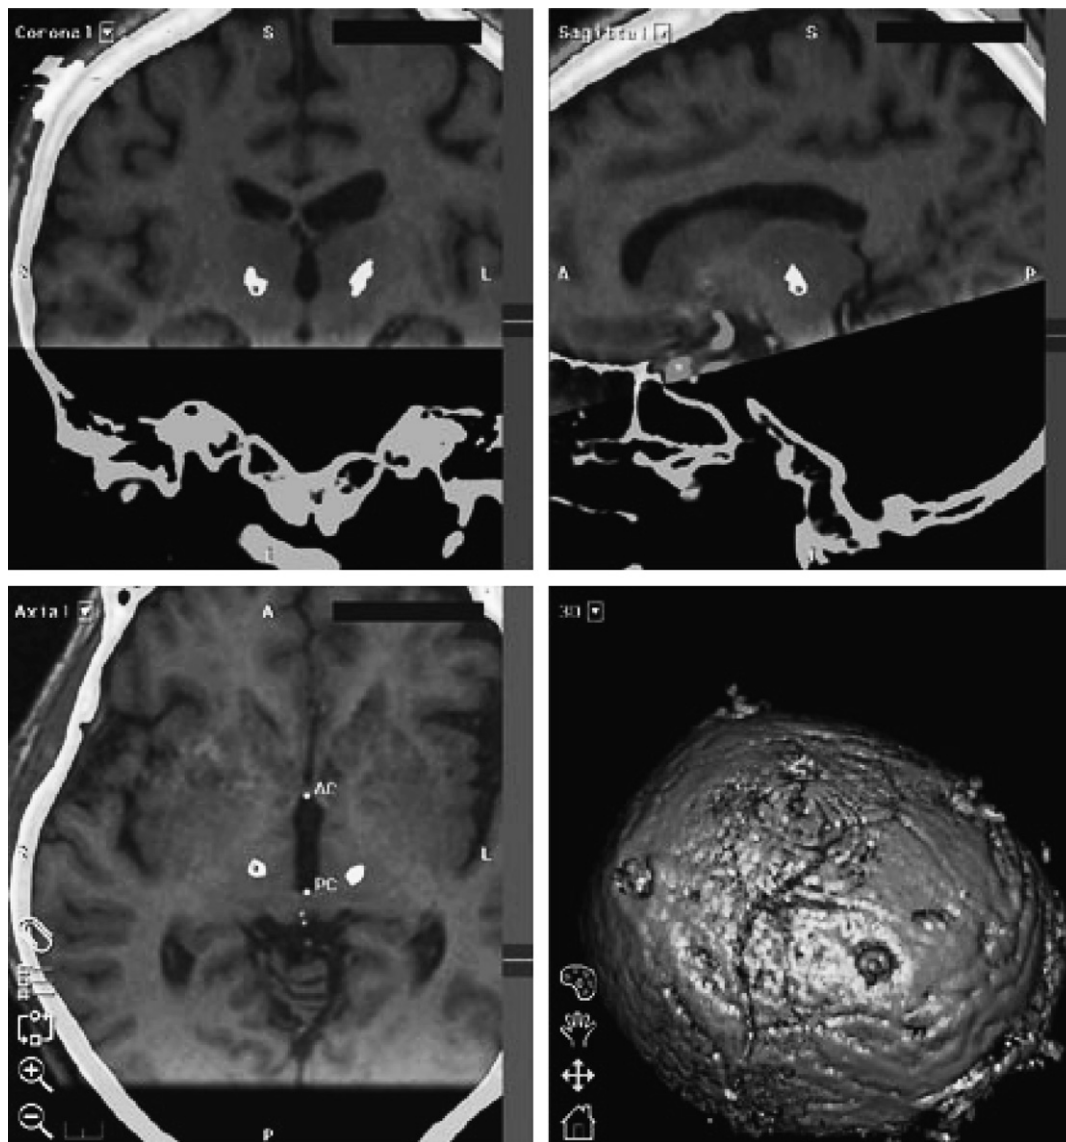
Postoperative CT merged with preoperative volumetric axial T1-weighted MRI demonstrating coronal, sagittal and axial views of both ventralis intermedius (VIM) deep brain stimulation electrode tips along with the 3D image reconstruction (depicting the skull fiducials) on the Stealth FrameLink 4.0 workstation (Medtronic Inc., Minneapolis, MN, USA). The calculated right-sided target (dark dot) is near the center of the electrode tip artifact (white). Similar results were obtained for the left VIM target (not shown).
